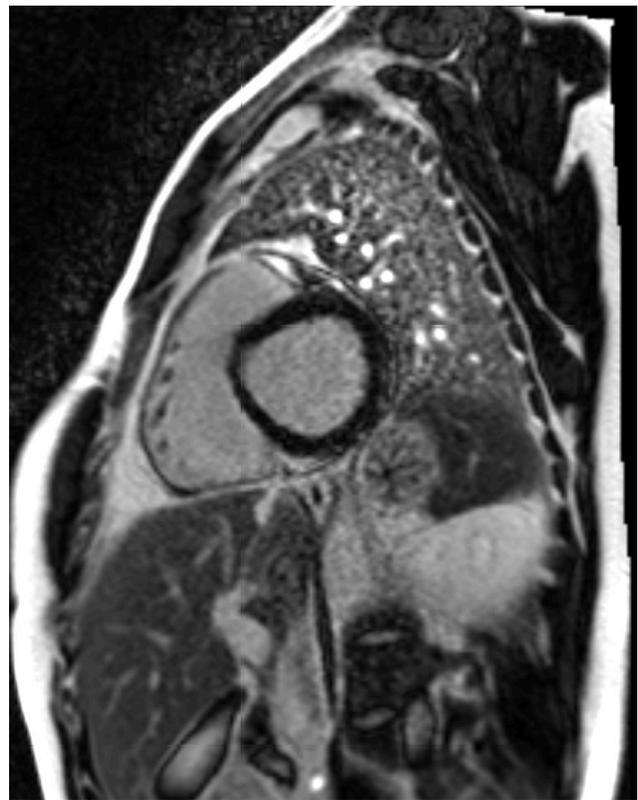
Limited epicardial late gadolinium enhancement in the basal inferolateral wall on cardiac MRI scan.
